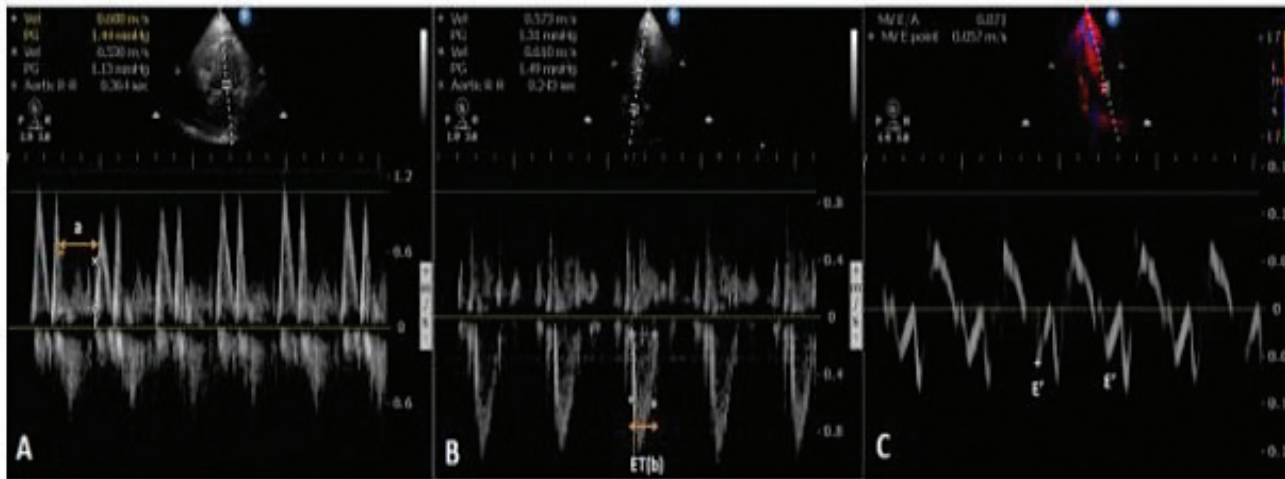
Measurement of MPI - (A and B); calculated (a-b)/b. (C) tissue Doppler-derived e'
